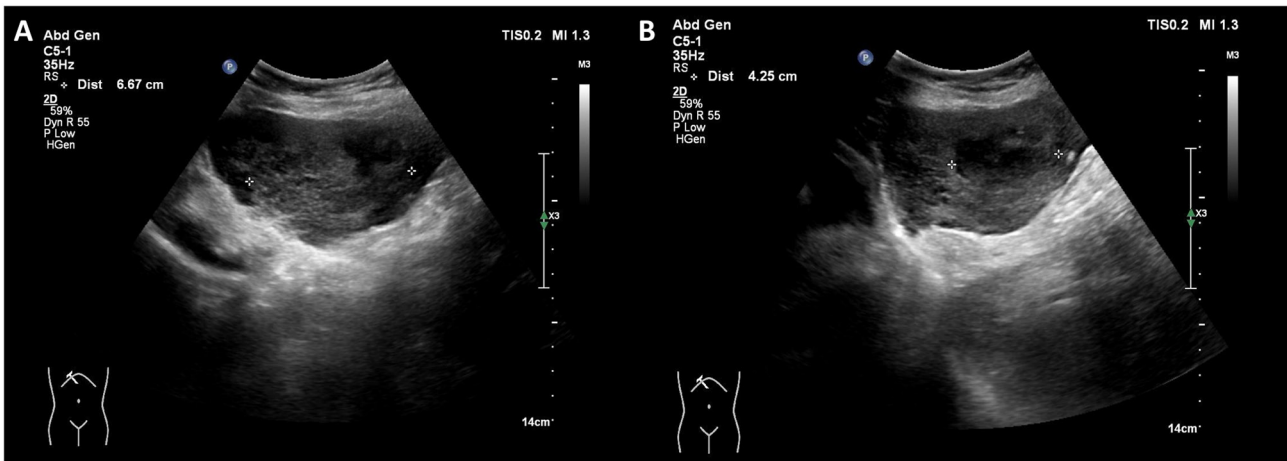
Abdominal ultrasonography showing two hypoechoic masses in the left lobe of the liver, incidentally identified during routine imaging. (A) Transverse view showing the larger hypoechoic mass with well-defined margins. (B) Longitudinal view highlighting the second hypoechoic mass with a heterogeneous echotexture.
